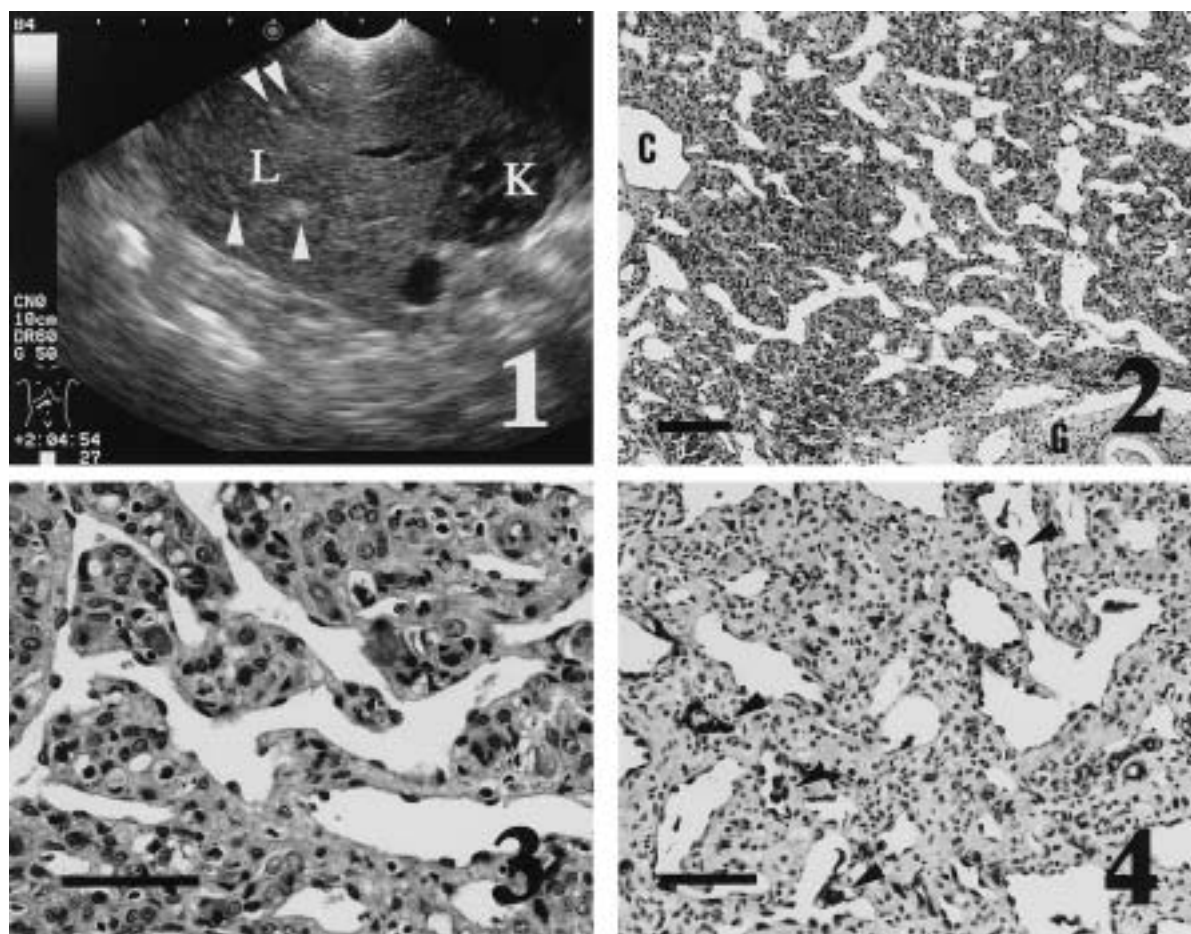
Hepatic ultrasonography. Congestion and increased parenchymal echogenicity with focal and more hyperechoic nodules (arrowheads). L: Liver, K: Right Kidney.
